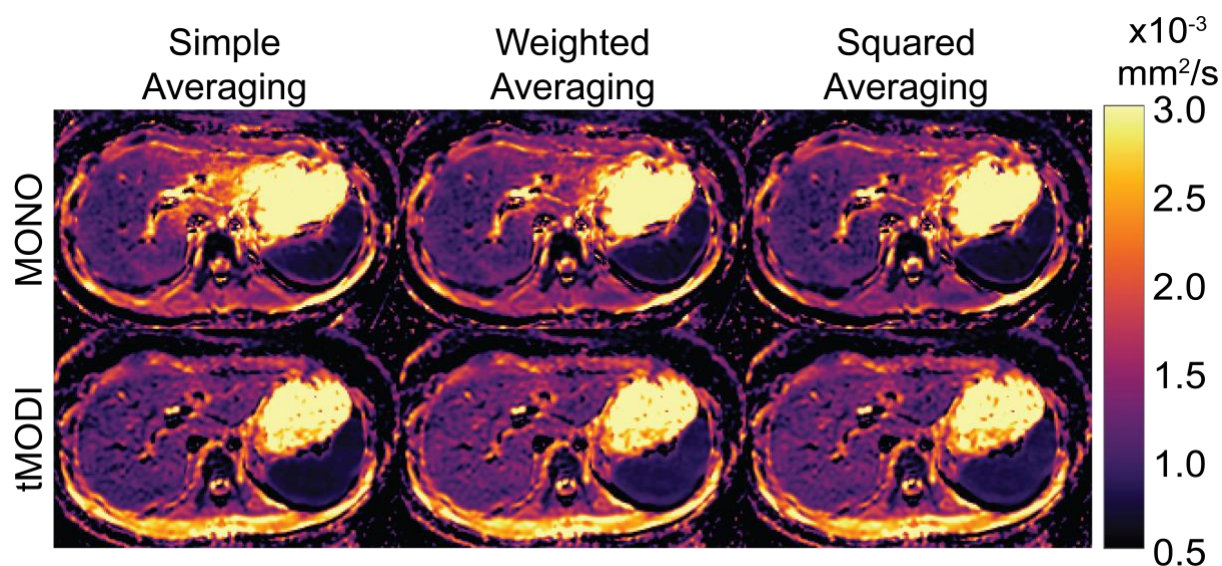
Example ADC Maps Using Various DWI Acquisitions and Averaging Techniques. Example ADC maps from one healthy volunteer on a single scanner demonstrate the overestimated ADC in the left lobe of the liver using MONO and reduction of this overestimation using tMODI. Applying weighted or squared weighted averaging helped to suppress the left-lobe overestimation in MONO but left-lobe ADC was still overestimated compared to tMODI with the same averaging technique. In this example, the tMODI acquisition largely avoided residual motion artifacts and the different averaging techniques show little ADC difference visually.
